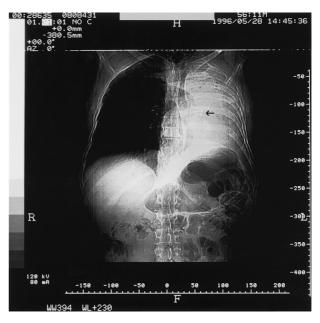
CT scanogram of the chest.
